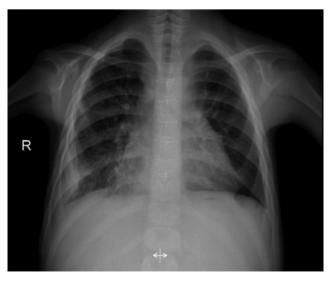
Bilateral diffuse infiltration and increased cardiothoracic ratio on posterior-anterior chest X-ray
